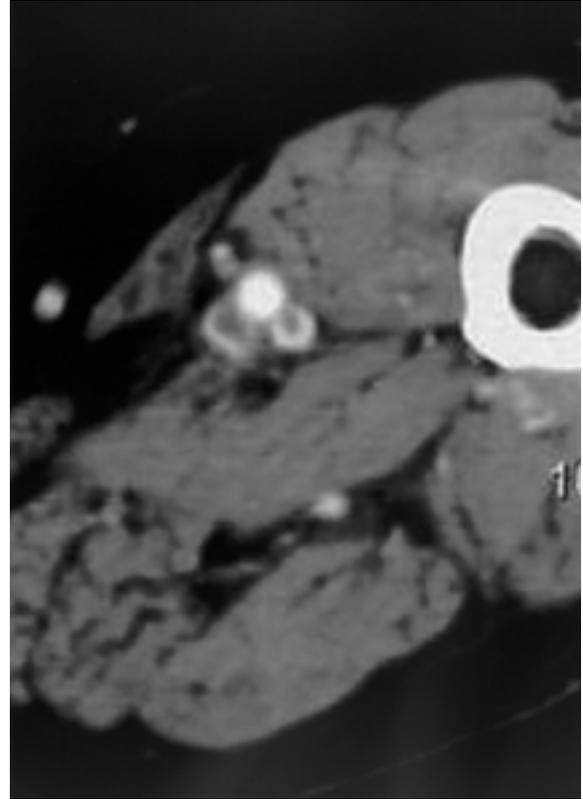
Pre-therapeutic CT scan shows duplication of superficial femoral vein, filled with thrombi.
